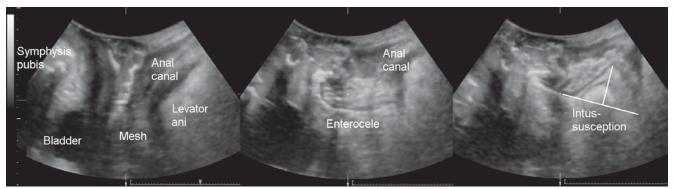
Rectal intussusception as evident in the midsagittal plane. Images are at rest (left), on mild Valsalva (middle) and maximal Valsalva (right). From Pelvic Floor Ultrasound. Springer Verlag, London 2007 with permission.
